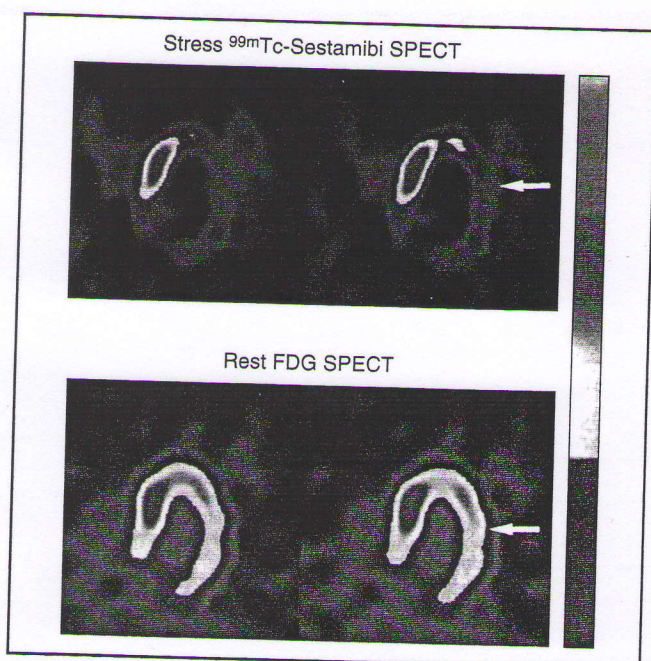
Patient study demonstrating "mismatch" of FDG (glucose metabolism) and sestamibi (perfusion) performed on a SPECT imaging camera (not a dedicated PET camera). There is decreased perfusion in the posterior lateral wall, but glucose uptake is preserved (viable myocardium). See also Color Insert.
